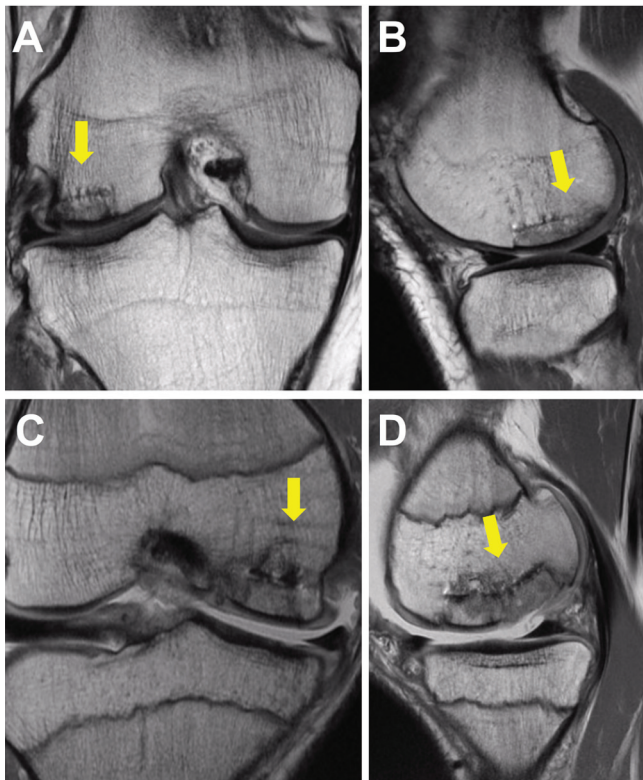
Representative 12-month coronal and sagittal magnetic resonance imaging sections in (A, B) a 20-year-old male patient, demonstrating crossing trabeculae and minimal subchondral bone marrow edema, and (C, D) a 16-year-old male patient, demonstrating discernible clefts at the host-graft junction and significant subchondral bone marrow edema. Both were treated with osteochondral allograft transplantation augmented with bone marrow aspirate concentrate. Arrows indicate host-graft junction.
